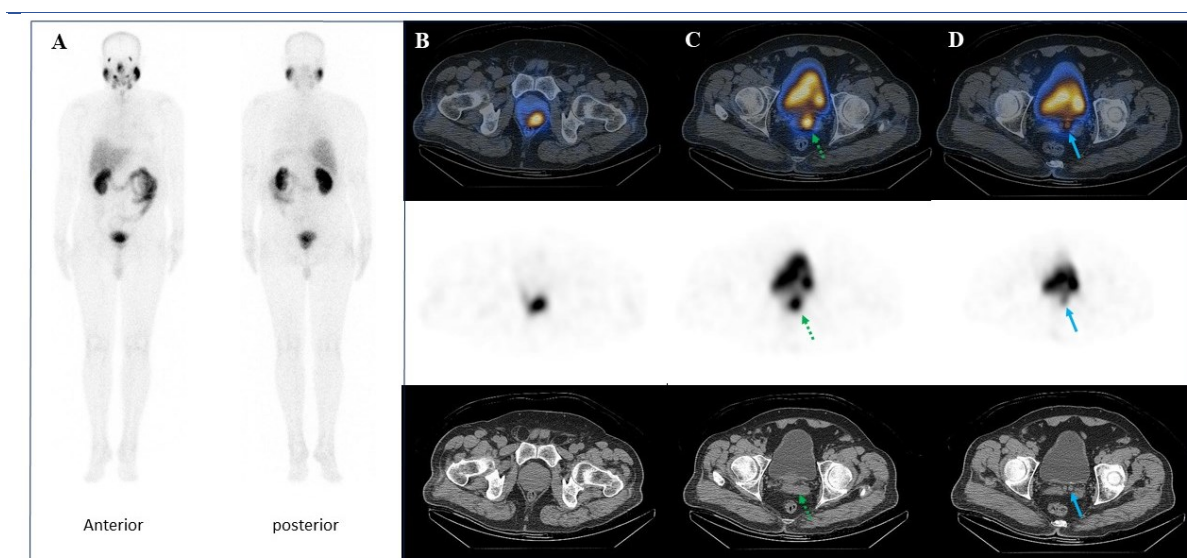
[^{99m}Tc]Tc-PSMA SPECT/CT images demonstrating findings consistent with PET/CT, including uptake in the primary prostate tumor (B), left seminal vesicle base (C, dotted arrows), and vas deferens ampulla (D, arrows)
